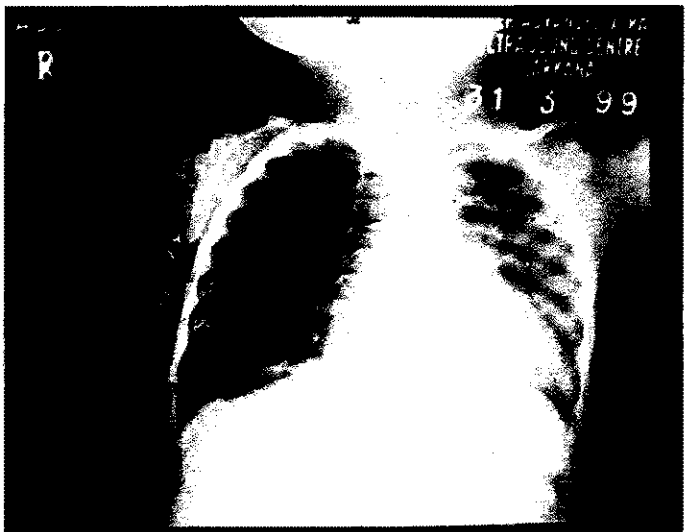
X-ray chest PA view showing a cystic lesion on right side.
